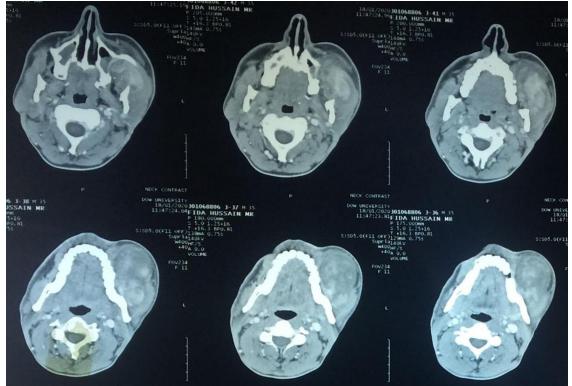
CT scan of face with contrast from base of skull to thoracic inlet revealed heterogeneous mass in the left buccal region, appearance suggestive of neoplastic lesion.
